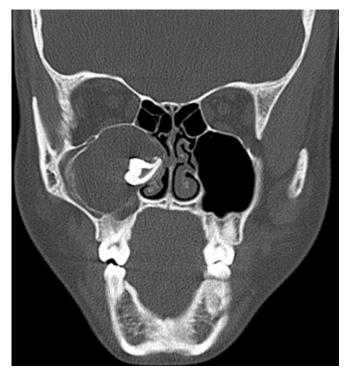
Coronal computed tomography image of a dentigerous cyst in the right maxillary antrum. Note the thin rim of bone along the inner margin of the true maxillary antral wall. This indicates that the lesion has its origin outside of the antrum.
